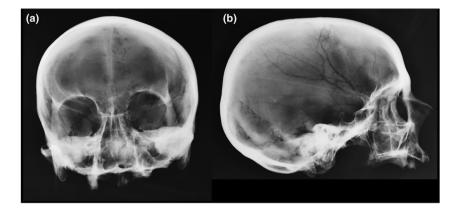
Frontal (a) and lateral (b) X-ray of the skull of Blessed Egidio da Laurenzana (1443–1518)
